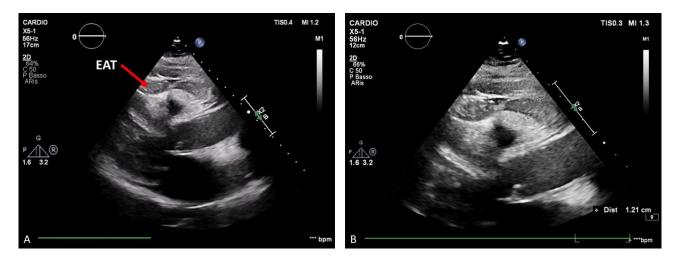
Two-dimensional echocardiography in parasternal long-axis view. Evidence of epicardial adipose tissue (arrow) (A); measurement of EAT thickness (B).
